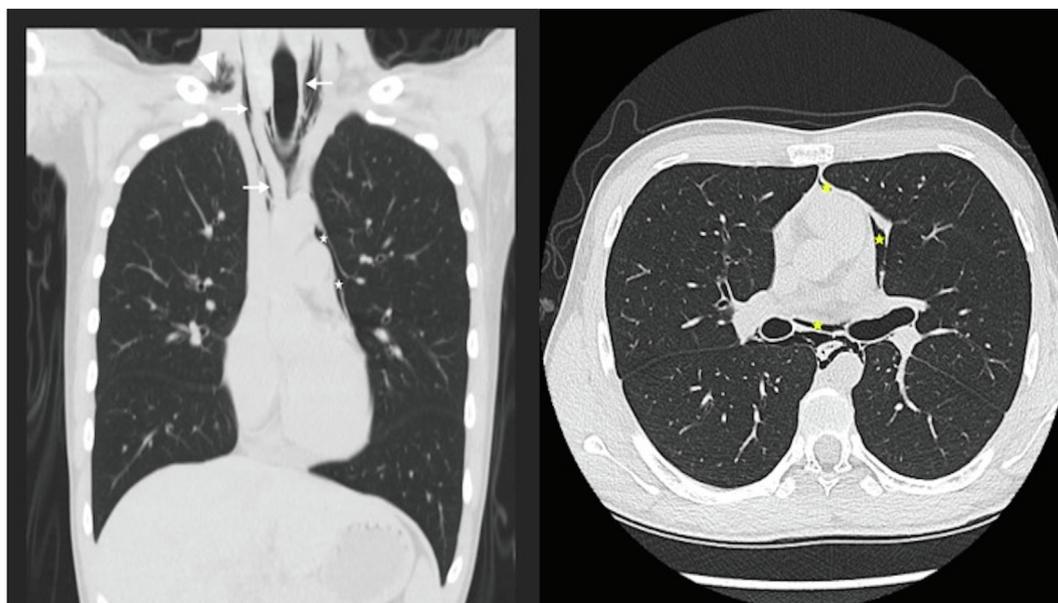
Coronal and axial high-resolution computed tomography demonstrated subcutaneous emphysema in the carotid space of the neck (white arrowhead), air accumulation in the mediastinum (white arrows), the superior pericardial cavity (white stars), and the surface of the heart (yellowish stars).
